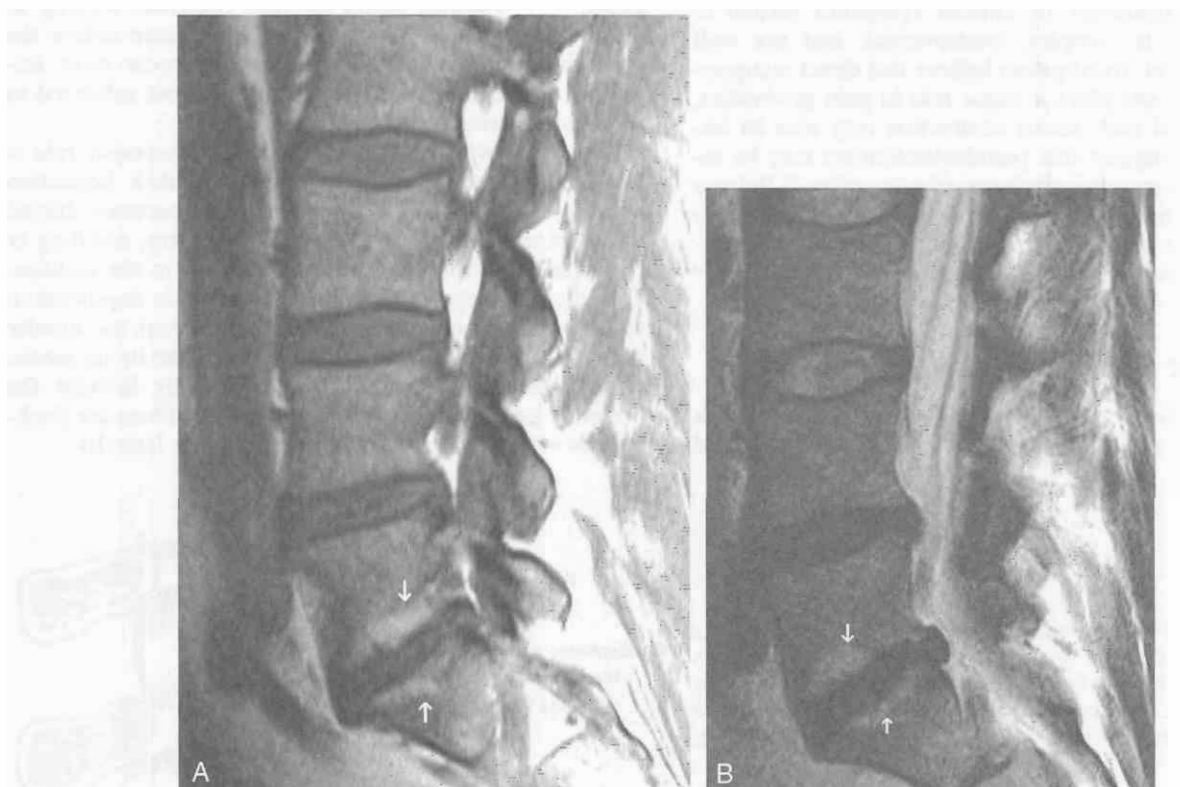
Type II end-plate changes. T1-weighted (A) and fast spin-echo, T2-weighted (B) MR images; show fatty end plates (*arrows*), which are hyperintense on T1-weighted and fast spin-echo, T2-weighted images.
